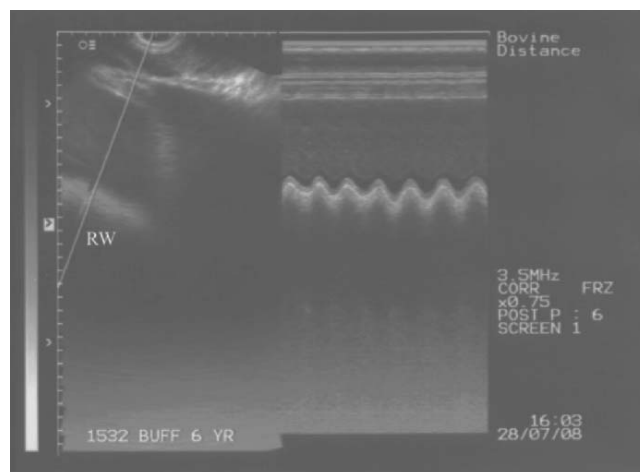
Ultrasonogram in B+M mode showing reticular wall moving with respiratory movements in the form of crists and troughs.
